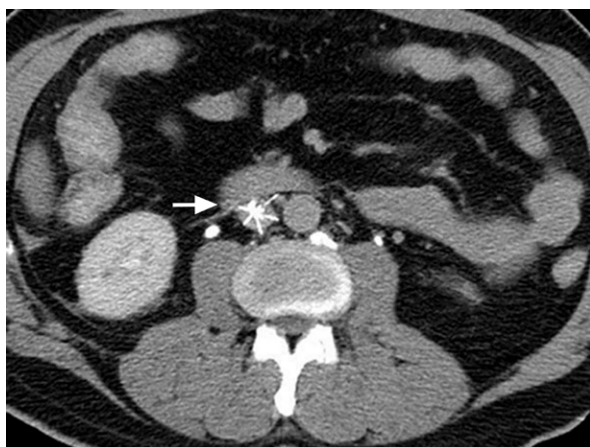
Computed tomogram of the abdomen shows the missing filter strut anteriorly (arrow).
